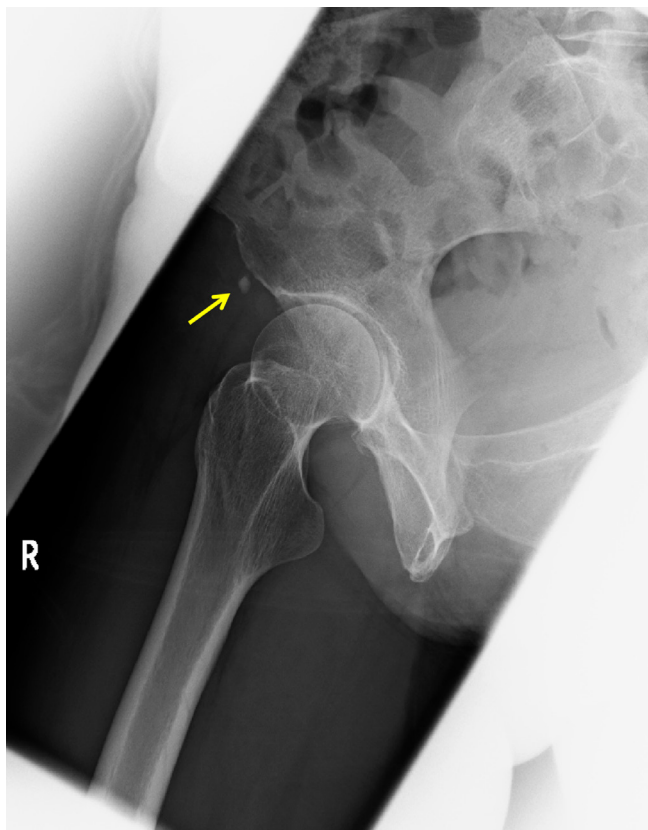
Radiography revealed calcifications near the right anterior inferior iliac spine (arrow).
